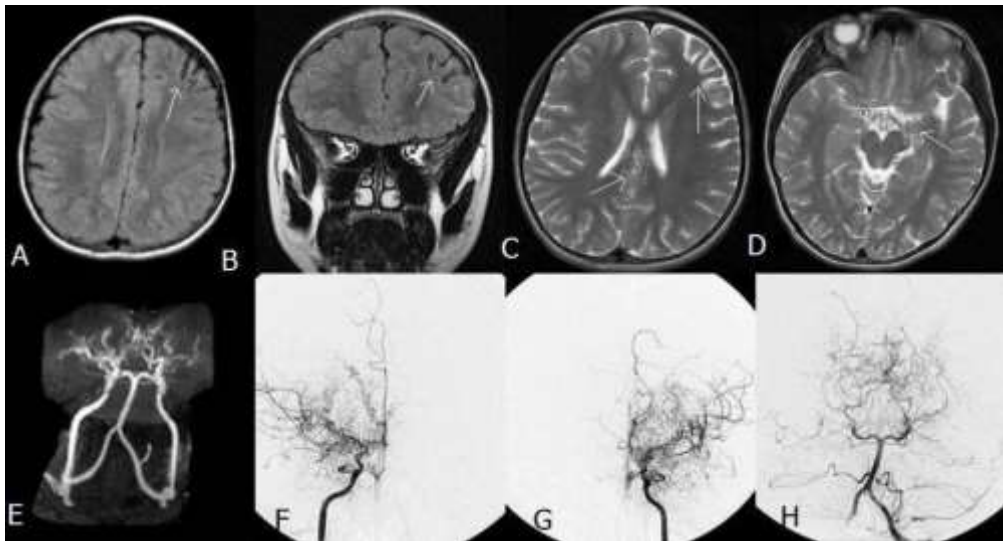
A 10-year-old, right-handed girl with left frontal old ischemic stroke who presented with a long-standing history of headaches with or without associated transient hemisensorimotor symptoms, frequently affecting left hemibody compared to the right side. A and B) MRI brain revealed evidence of volume loss on axial and coronal FLAIR sequences and (C) hyperintensity in the left frontal region on axial T2 sequences (arrows). The axial T2 sequences (C and D) and time of flight MR angiogram (E) reveal evidence of prominent tiny arteries and capillaries in the bilateral basal ganglia and parasagittal regions (arrows). F and G) The catheter cerebral angiogram on right and left internal carotid injections confirmed occlusion of bilateral distal internal cerebral arteries with reconstitution of the middle cerebral artery proximal segments via the deep arterial anastomosis and evidence of capillary collaterals and prominent hypertrophic deep perforating arteries giving the classical picture of moyamoya (or puff of smoke). G) The left vertebral artery injection show similar hypertrophic perforating arteries and new sprouting capillary collaterals.
